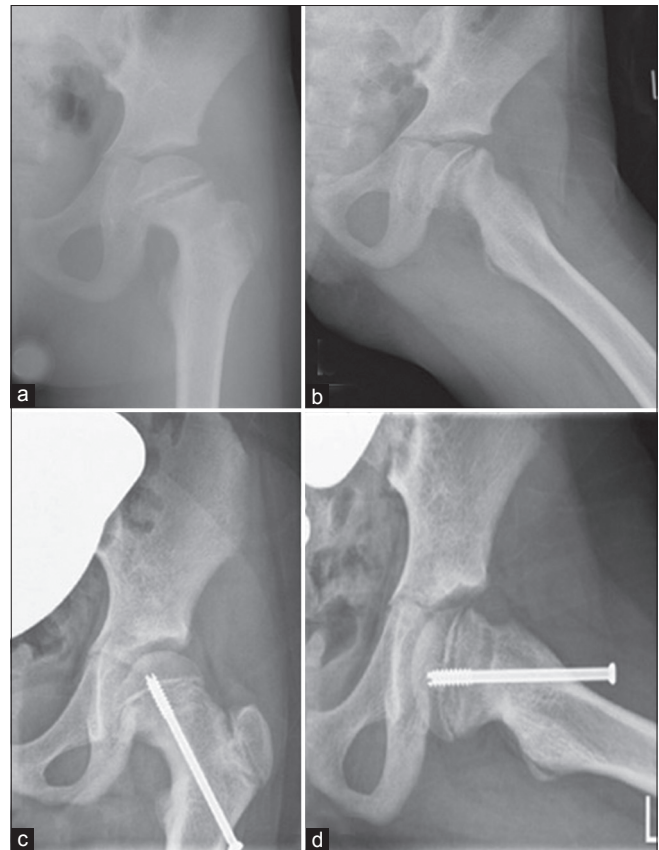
Radiographs (anteroposterior and frog leg lateral) in 8-year-old female showing (a,b) slipped capital femoral epiphysis (c,d) good remodeling of the head of the femur at 2 years followup
